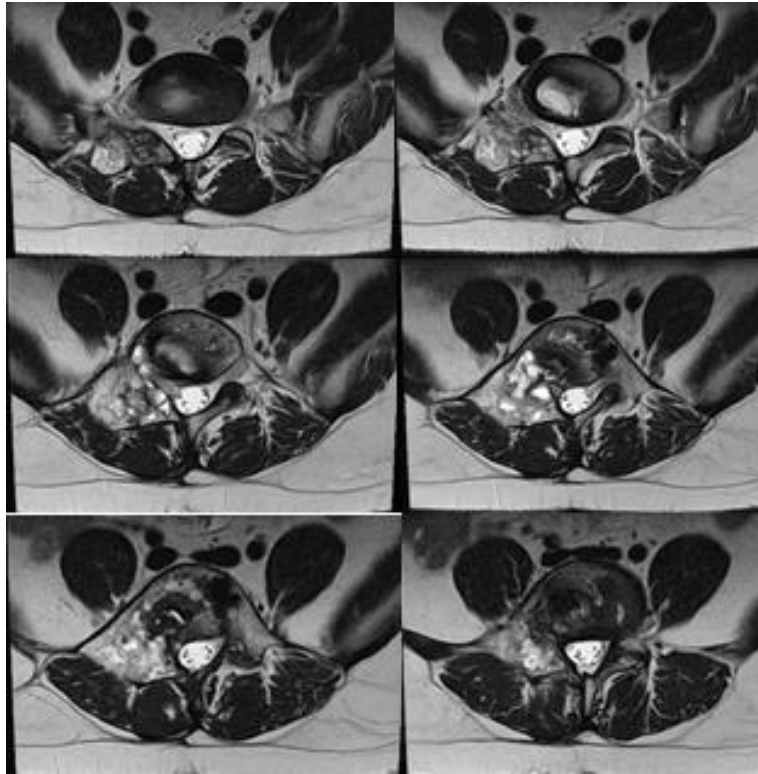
MRI of the spine after 1 year of IMRT/ 22.05 24. The observed heterogeneous volumetric formation presents without dynamics in its axial dimensions of 4.3 / 7.9 cm compared to the transitional axial dimensions of 4.3 / 8.4 cm and with some progression of the cystic components. The structure of the formation is markedly heterogeneous with cystic and reticular osteosclerotic areas.
